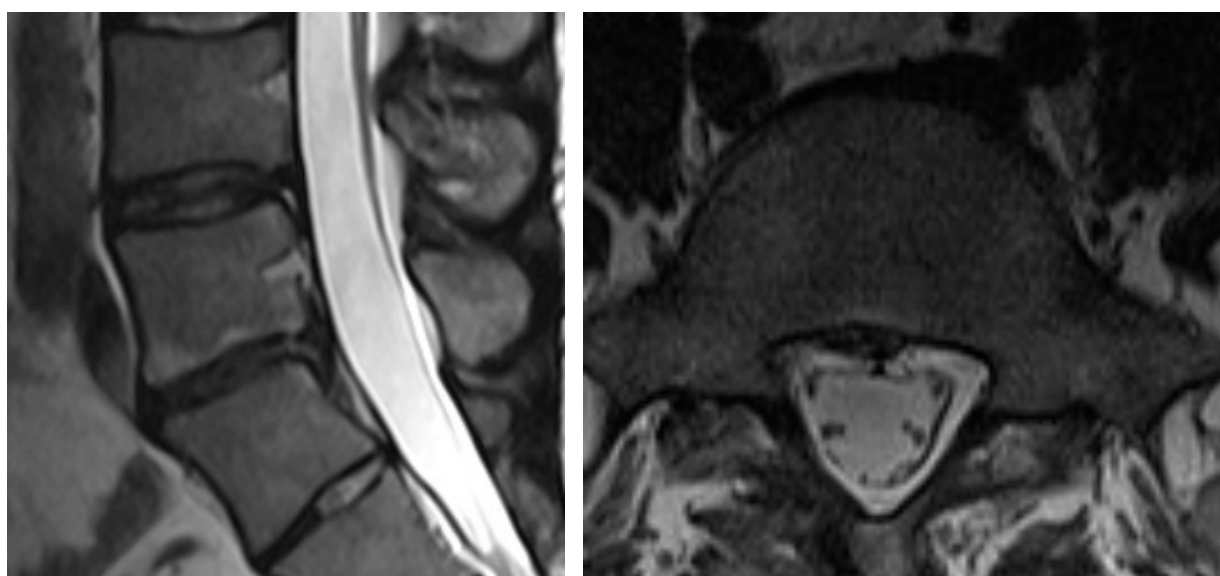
Magnetic Resonance Imaging [MRI] of lumbar spine, two months after operation: Complete resolution of the herniated disc Large herniated disc at the level L5/S1 with caudal migration
